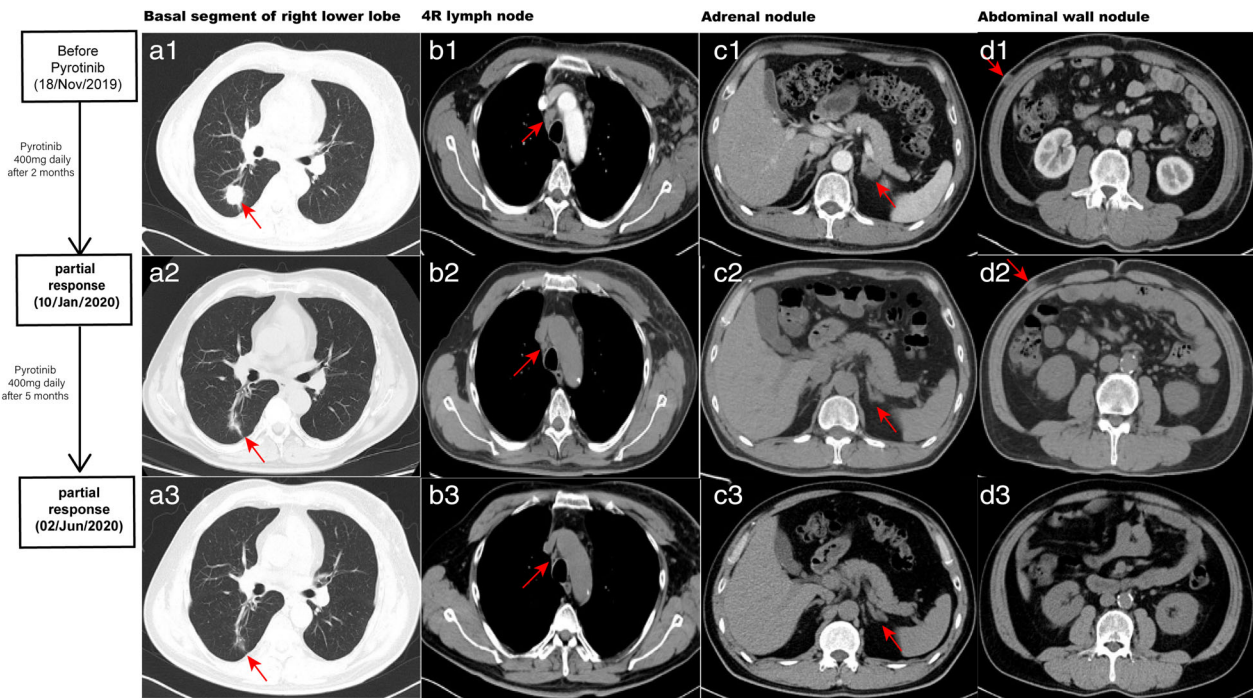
Computed tomography scans of the patient before pyrotinib and follow-up after pyrotinib treatment. Red arrows highlight the targeted lesions
